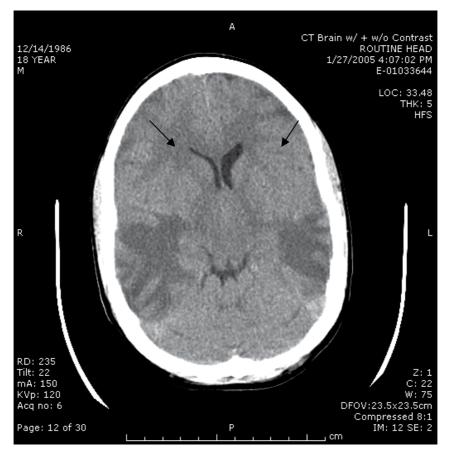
An 18 year old male with ALL in 3rd remission following an unrelated bone marrow transplant. His conditioning regimen consisted of TBI 1360cGy. Four months post-HSCT he developed seizures and a coma.. An MRI of his head showed bilateral lesions in the deep subcortical white matter of the temporal lobes. The MRI findings are consistent with progressive multifocal leukoencephalopathy
